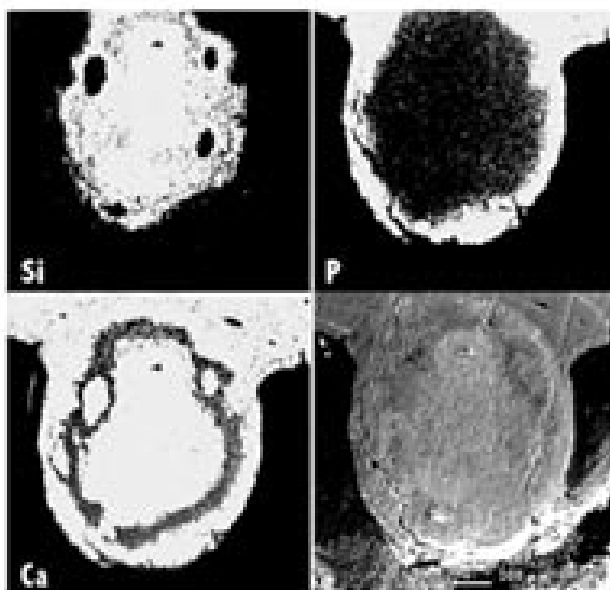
SEM image of a cross-section of pseudowollastonite implant after six weeks of implantation and X-ray elemental map of Si, Ca and P
